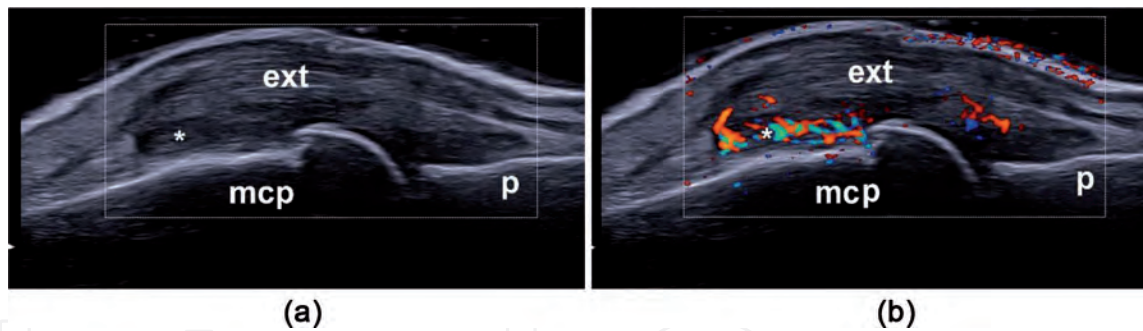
Ultrasonography of the metacarpophalangeal joints in GS mode (left) and power Doppler (right), with periextensor tendon inflammation (PTI pattern - asterisk). mcp – Metacarpal bone, p – Phalanx, ext. – Extensor tendon.
